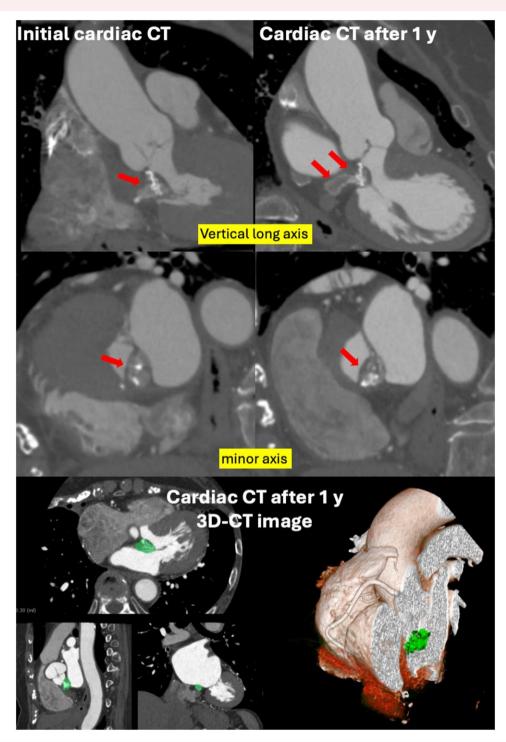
Cardiac computed tomography displays a calcified mass. The mass seems to extend to the posterior of the left atrium and non-coronary cusp.
